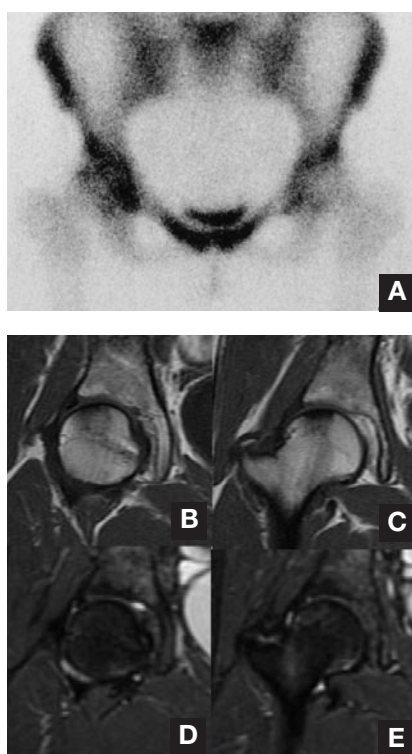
(A) High-uptake lesion was seen in bone scintigram at the femoral head. There was a low-signal area in the upper part of the femoral head both in T₁-weighted (B, C) and T₂-weighted (D, E) magnetic resonance images. There were no findings of bone marrow edema in the acetabulum.
